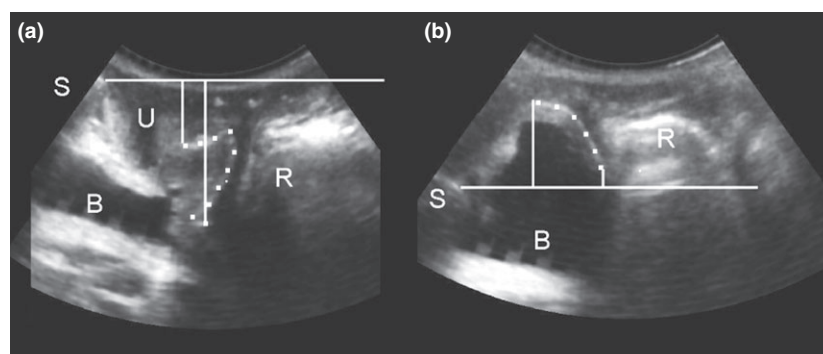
Mesh imaging on translabial ultrasound at rest (a) and on Valsalva (b). The Anterior Elevate mesh is identified by the dotted line. Mesh position is measured against the reference of the inferoposterior symphyseal margin. The vertical lines show the positions of cranial and caudal mesh aspects. B, bladder; R, rectum; S, symphysis pubis; U, urethra.
